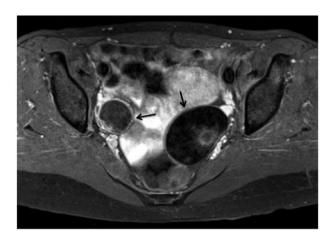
Abdominal magnetic resonance imaging of a 20-year-old woman who developed acute psychotic symptoms and altered level of consciousness, and was diagnosed with anti-N-methyl-Daspartate receptor encephalitis. The image shows bilateral ovarian teratomas (arrows).
